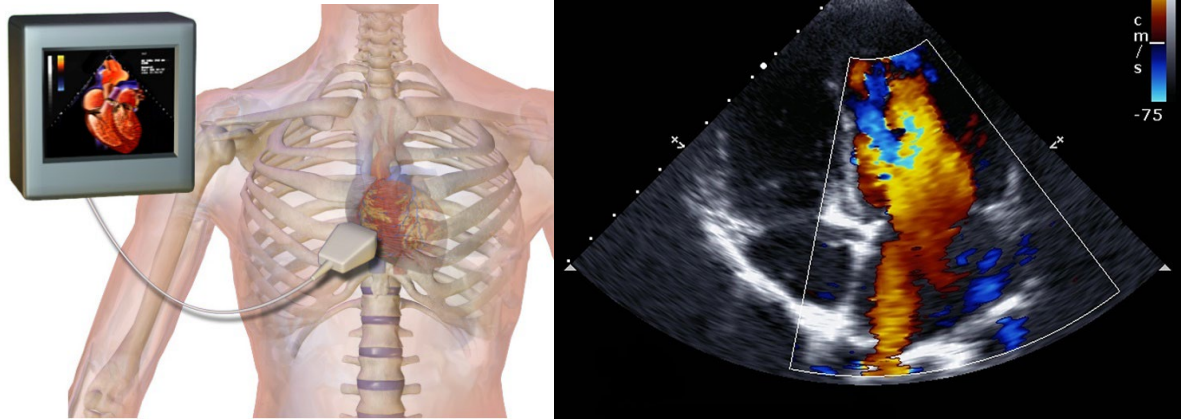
Echocardiography, a technique using ultrasound to produce scans of the heart (BM, 2017; HPMC, 2015).
